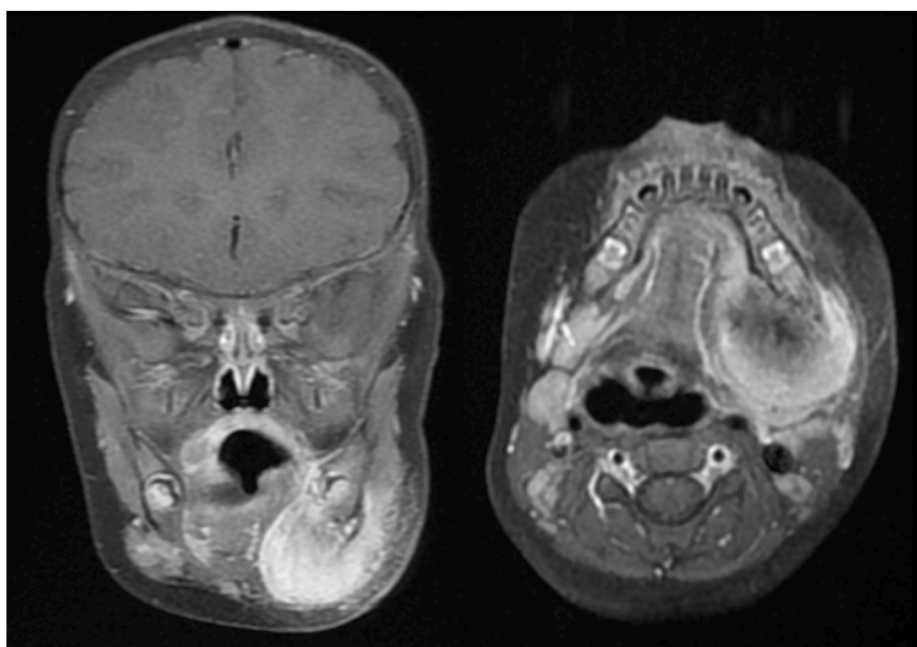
MRI findings of submandibular lesion.
